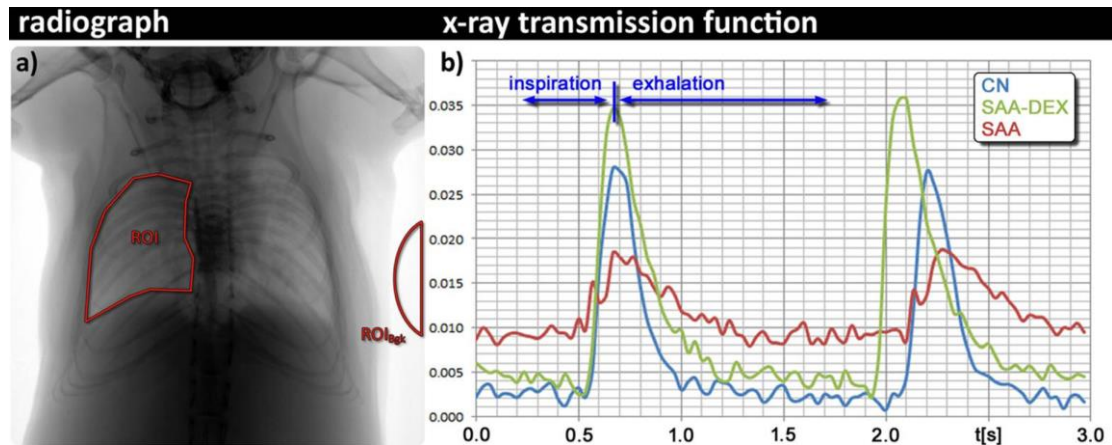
Breathing induced modulations in the x-ray transmission at the chest region over time.
